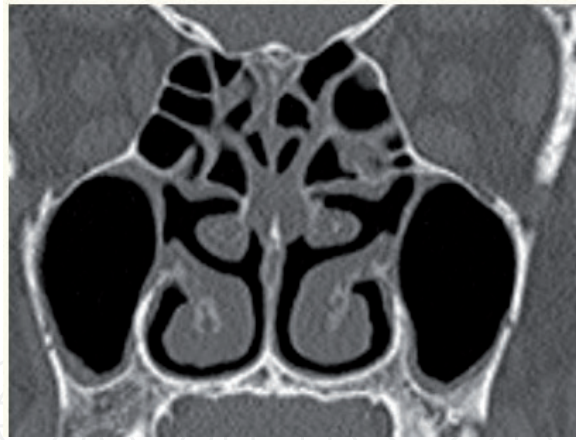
The radiologic study with head-CT shows a normal anatomy of the turbinates and the nasosinusal system.
